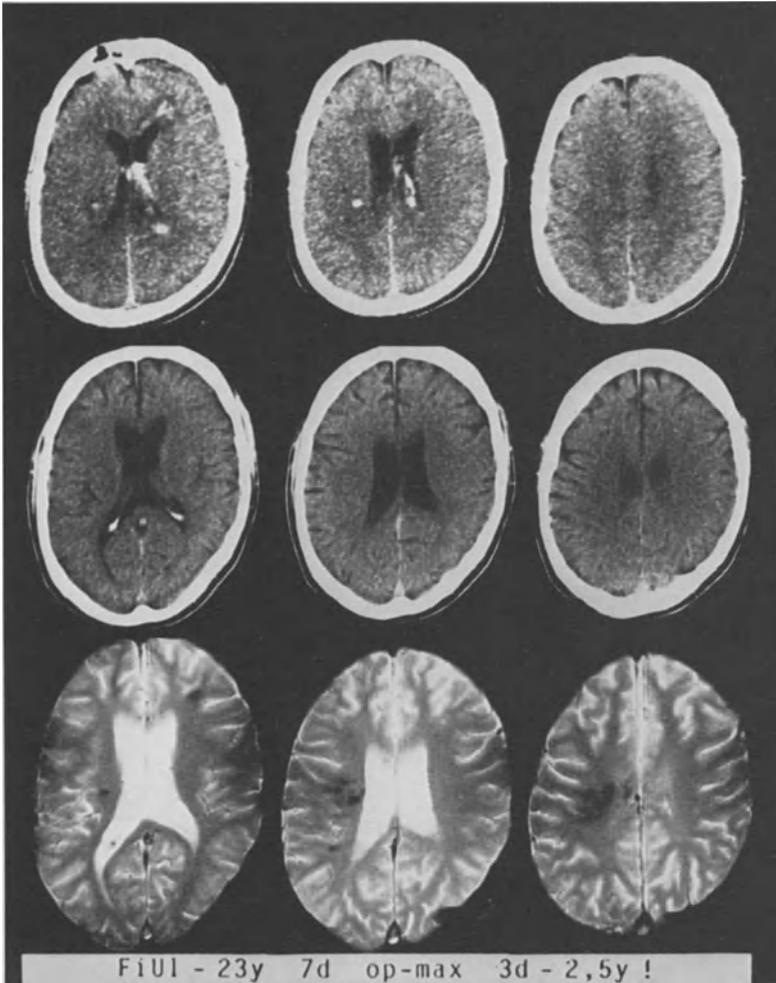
Imaging of posttraumatic intracranial bleedings (intracerebral, intraventricular, subarachnoid): follow-up with CT compared with MRI after 30 months. Residua of the initial bilateral periventricular hemorrhages remain more clearly visible in the MRI than in the CT scans. Bleedings with direct contact to the cerebrospinal fluid seem to behave differently (washed out effect). FiUl, initials; 23 y, age at the time of accident: 23 years; 7 d, 1 week of posttraumatic coma; op-max, maxillofacial surgery because of mandibular fractures; 3 d, CT control after 3 days (above); 2.5 y, reexamination after 30 months by CT (middle) and MRI (below). Clinical outcome: good recovery. EEG: pathological with diffuse dysrhythmia
